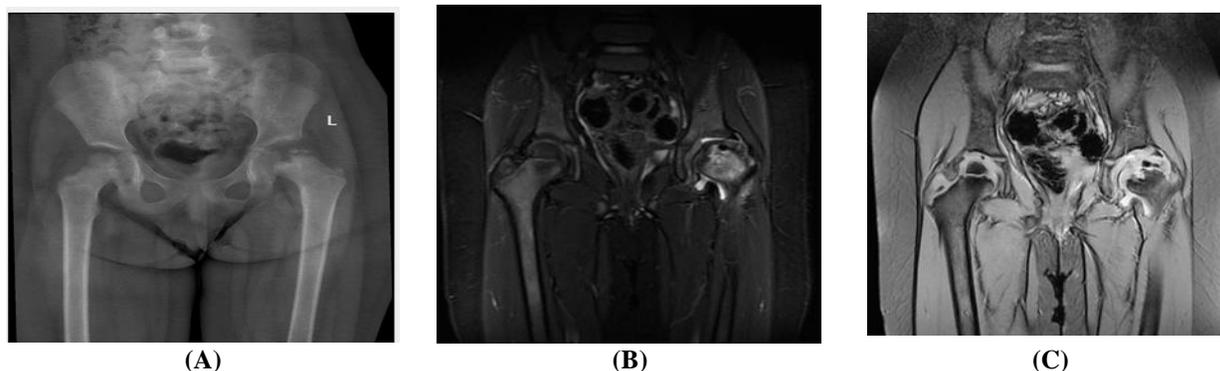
A known case of sickle cell disease of 3 years old girl complaining of limping and limitation of left hip joint movement. (A) Radiography of both hip joints AP view showing flattened, sclerotic and fragmented left femoral capital epiphysis. (B&C) MRI coronal STIR and coronal gradient respectively showing the proximal left femoral epiphysis is flattened, sclerotic and fragmented associated with thick/hypertrophic articular cartilage. The proximal metaphysis shows irregularity with cyst/pseudocyst formation containing cartilage signal. Ipsilateral moderate joint effusion with contralateral incidentally finding mild right hip joint effusion.
